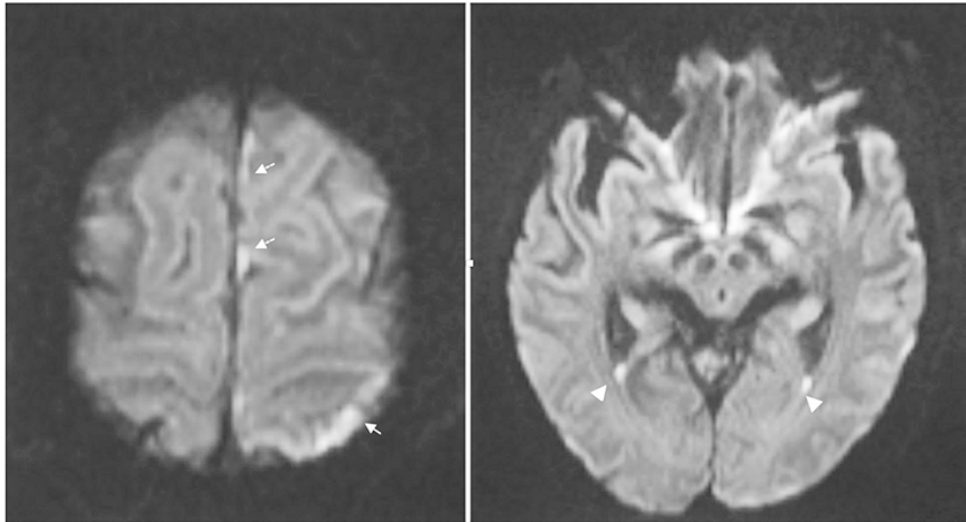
MRI of the brain showing restricted diffusion provoking concern regarding debris/pus formation along the left frontoparietal sulci (arrow), interhemispheric falx (dashed arrows), and bilateral occipital horns of the lateral ventricles (arrow heads).
